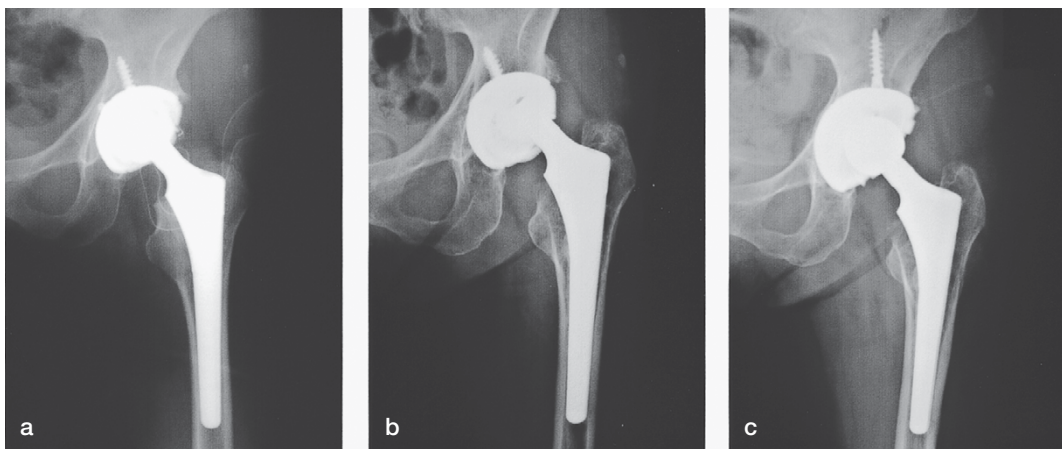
Radiographic findings.
